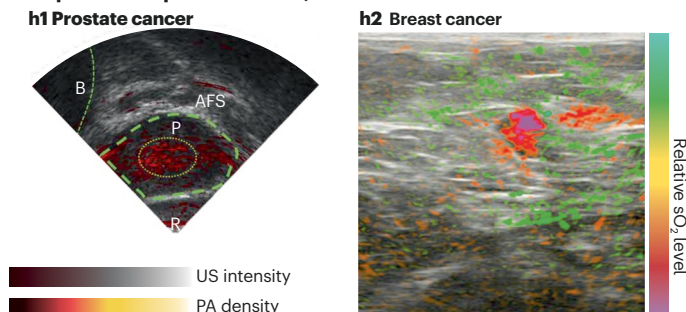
Representative clinical photoacoustic imaging results for human functional systems. a, Integumentary system. a1, Photoacoustic and ultrasound (PAUS) image of a melanoma⁴⁰. a2, Photoacoustic (PA) images of a healthy volunteer and a patient with psoriasis⁸⁷. b, Musculoskeletal system: 3D PA images of a healthy volunteer and a patient with Duchenne muscular dystrophy (DMD)⁴⁴. c, Cardiovascular system: PAUS images of a healthy volunteer and a patient with carotid atherosclerosis¹³⁵. The arrow points to the region of increased total haemoglobin (HbT). d, Lymphatic system. d1, PA image of the lower limb of a 75-year-old woman with secondary lymphoedema²⁴⁴. d2, PAUS image of a sentinel lymph node after indocyanine green (ICG) injection¹⁴¹. e, Nervous system: 3D maximum amplitude projection PA and magnetic resonance angiography (MRA) images of a volunteer after post-hemicraniectomy⁸³. f, Endocrine system: PAUS images of a benign nodule and papillary thyroid cancer⁴⁷. g, Gastrointestinal system: PAUS images of Crohn's disease in remission and active Crohn's disease (both according to Simplified Endoscopic Score for Crohn's Disease)¹⁴⁸.
